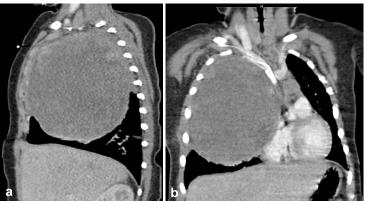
Chest CT scan showing the presence of a mixed mass in the right superior lobe whit adherence on the anterior-lateral pleura. CT: Computed tomography.
